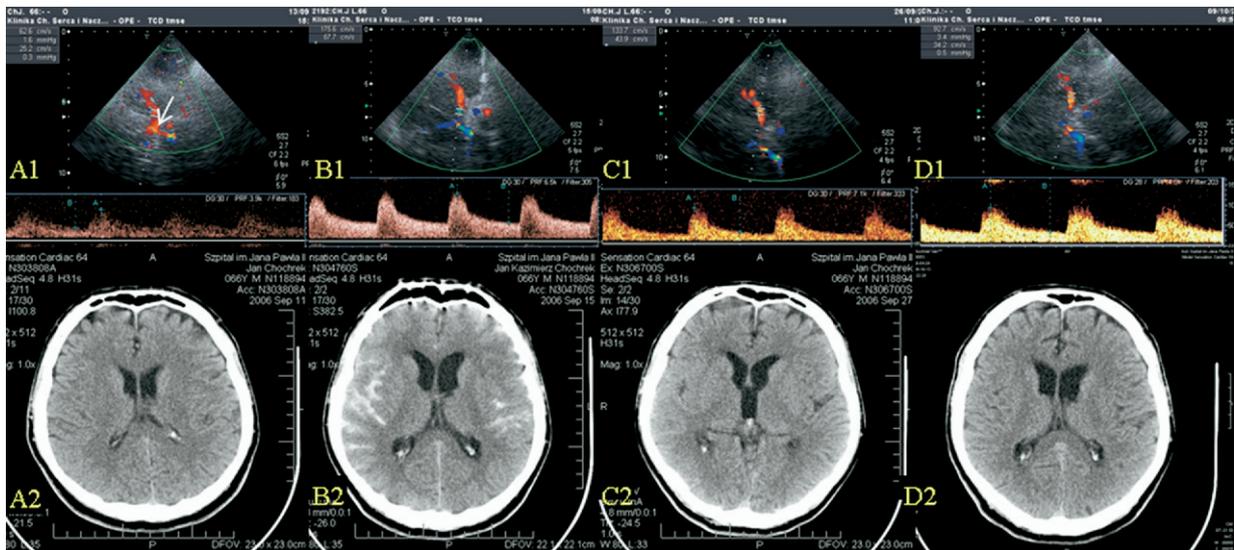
Images in the upper row present TCCD findings: A1, prior to CAS, decreased PSV (62 cm/s) in the right MCA, posterior communicating artery (arrow); B1, after CAS, 2.8-fold PSV increase in the right MCA (PSV-175 cm/s); C1, 2 weeks after CAS, slow decrease of MCA PSV (133 cm/s); D1, 4 weeks after CAS, normalization of the right MCA PSV (92 cm/s) Images in the lower row present CT findings: A2, prior to CAS, normal CT scan; B2, after CAS, subarachnoid hemorrhage with bilateral hemisphere edema; C2, 2 weeks after CAS, the right hemisphere edema, previously seen blood is absorbed; D2, 4 weeks after CAS, complete lesions' resolution.
